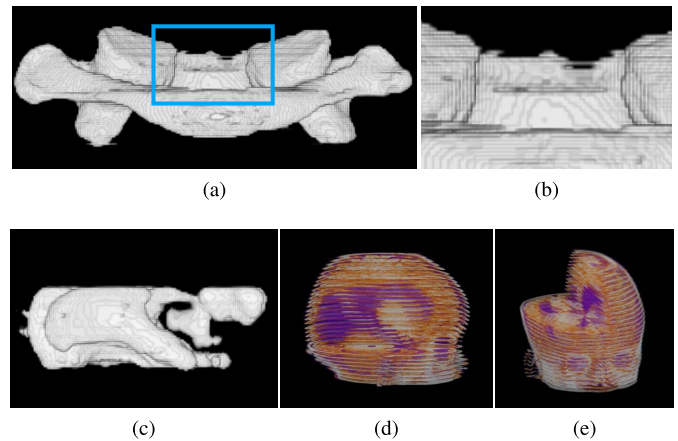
Interpolation by surface diffusion in gaps using an SDF. Vertebra from a CT-scan: (a) view from the front, and (b) zoom of the highlighted part of (a), and (c) brain ventricles from an MRI dataset, viewed from the side. Both datasets are made up of parallel slices. The brain dataset is shown in (d) from the side and (e) from the front, with parts removed in order to allow a better visualization of the ventricles, in purple.
